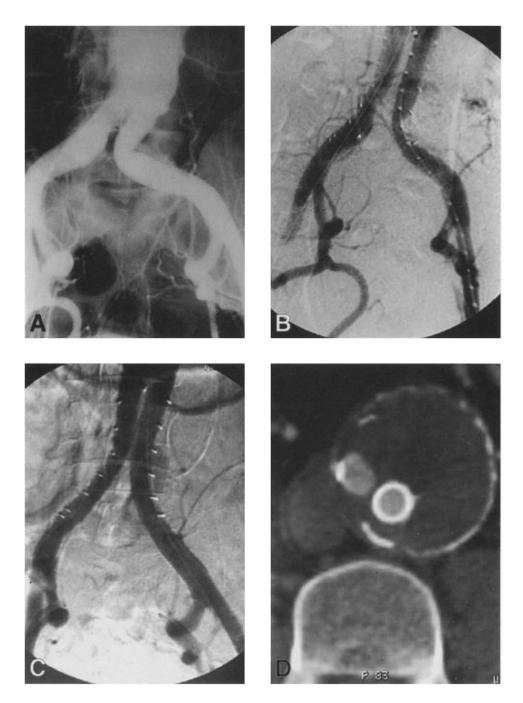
Example of endograft limb kinking. A, Preoperative angiogram shows angulation of left common iliac artery. B, Intraprocedural angiogram demonstrates kinking of endograft limb within angulated native arterial segment. C, Correction of compromised flow with insertion of Wallstent device. D, Postprocedural CT scan reveals widely patent left stented endograft limb within excluded abdominal aortic aneurysmal sac.
